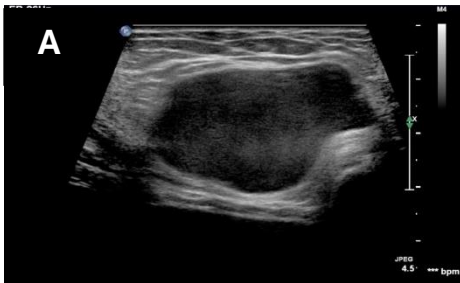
Transverse grayscale ultrasound of left inguinal demonstrating a well-defined unilocular anechoic lesion with posterior enhancement. No internal vascularity demonstrated on color Doppler.
